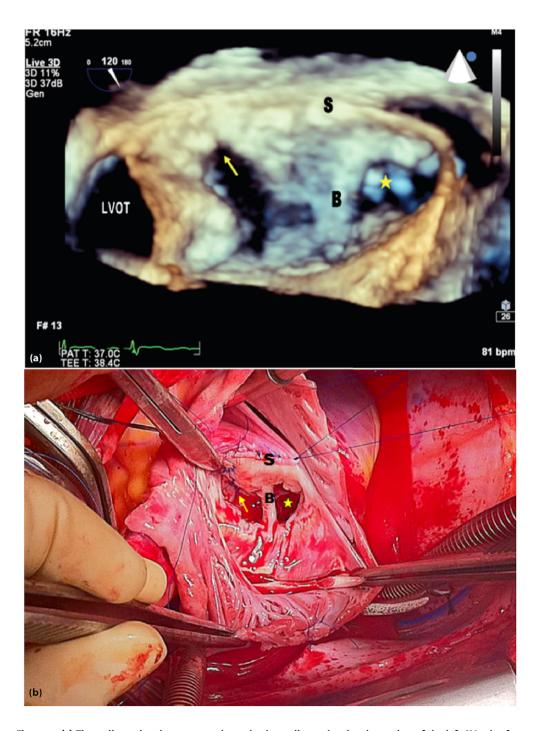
(a) Three-dimensional trans-oesophageal echocardiography showing a view of the left AV valve from the left atrium. Arrow: cleft in the larger anterolateral orifice. Star: smaller posteromedial orifice. B: Bridge in between two orifices. S: Atrial septum. LVOT: Left ventricular outflow tract. (b) Surgical view of the left AV valve. Arrow: the cleft closed (in the larger anterolateral orifice). Star: smaller posteromedial orifice. B: Bridge in between two orifices. S: Atrial septum closed by a pericardial patch.
